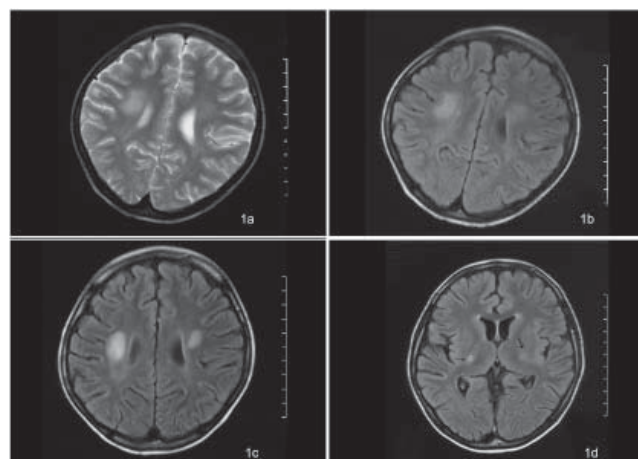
MRI scan at presentation showed bilateral white matter hyperdensity in the frontal lobes at the level of corona radiata extending to the centrum semiovale on T2-weighted images and T2-FLAIR (Fig. 1a and 1b). MRI scan at recurrence of MTX neurotoxicity showed bilateral deep white matter, basal ganglia and thalamic hyperdensity on T2-weighted FLAIR (Fig. 1c and 1d)
